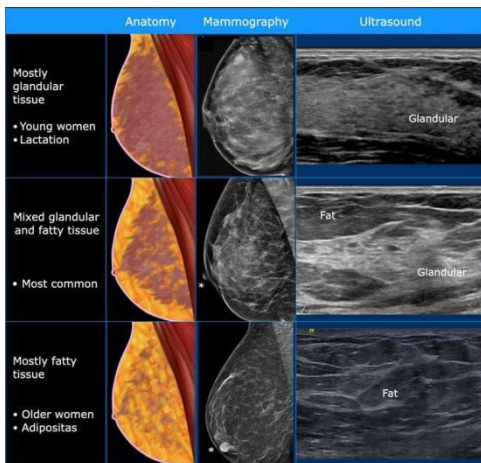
Breast Ultrasound
